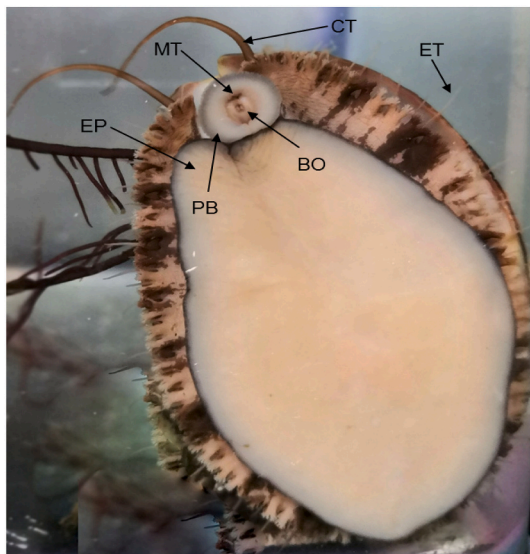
Sample image obtained from videos of feeding organs of *H. discus hannai*. MT: mouth; EP: epipodium; PB: proboscis; BO: bulbus oris; ET: epipodial tentacle; CT: cephalic tentacle.
